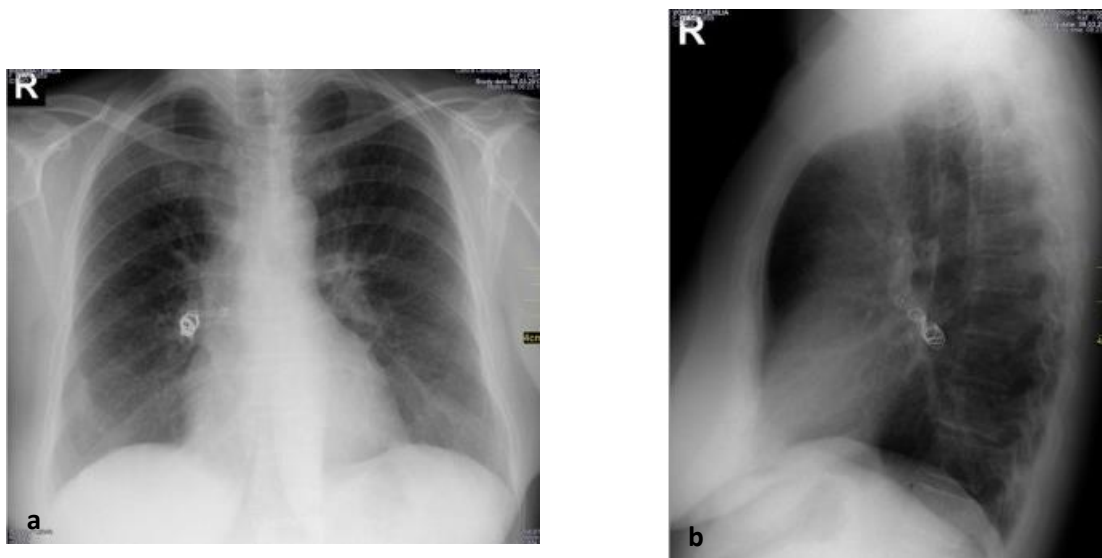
Radiological aspects after the intervention postero-anterior (a) and lateral view (b) of chest X-ray with the unspun coil.
